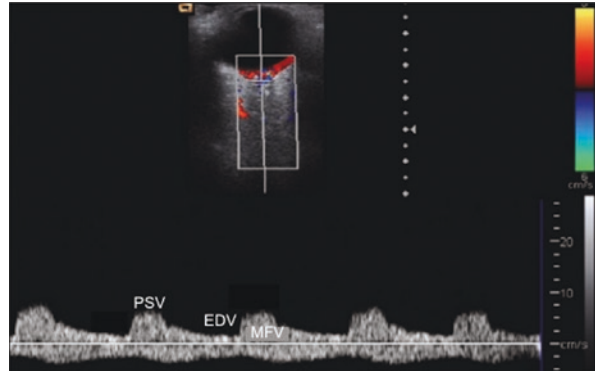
OCCS: Ophthalmic Artery insonation and spectral doppler wave; Typical OA waveform obtained by PW Doppler that shows a Sharp peak systolic, a dicrotic notch, and a relatively little flow in diastole. [Alaising effect], (MFV) Mean flow velocity, (PSV) Peak systolic flow velocity and (EDV) diastolic flow velocity. (Courtesy: Jiménez Aragón et al. [32])
